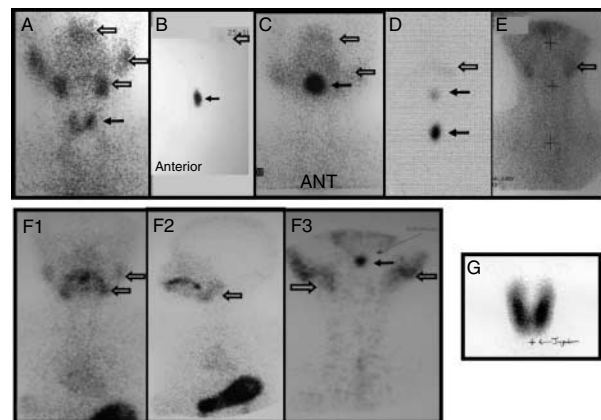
Thyroid scan pictures showing different types of thyroid dysgenesis. At upper panel hypoplasia (A), hemiagenesis (B), ectopia (C), double ectopia (D), and athyreosis (E) compared with normal thyroid (G) shown at lower panel. Panel F showing scintigraphy performed at the time of diagnosis (F1 and F2) reported as hemiagenesis while repeated scintigraphy at the time of the study (at 12 years age) showed ectopia (F3). Radiopharmaceutical uptake by thyroid tissue is shown by black arrows and salivary glands by empty arrows.
